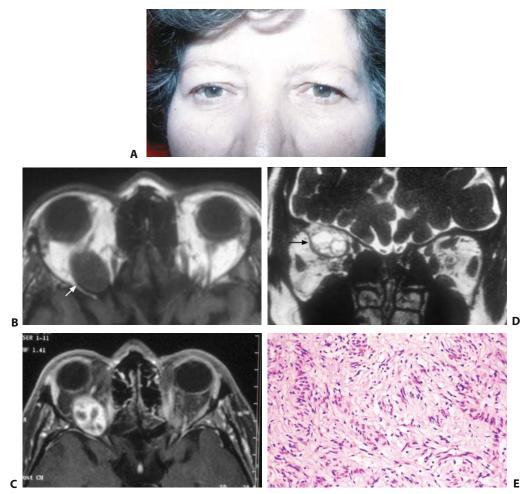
A 43-year-old woman with right orbital schwannoma. (A) Preoperative facial photograph of the patient with 2 mm proptosis of the right eye. (B) T1-weighted axial MR image showing the fusiform schwannoma isointense to the extraocular muscle and cerebral gray matter (arrow). (C) T2-weighted axial MR image showing the schwannoma hyperintense to the extraocular muscle and cerebral gray matter. Antoni B portions demonstrate a higher
